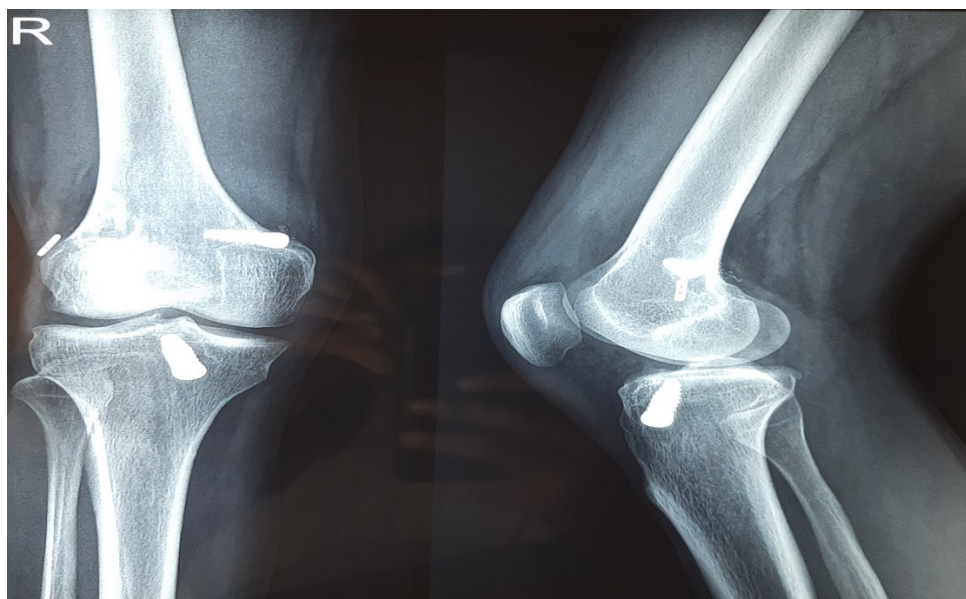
Postop X-Ray (1 Year Follow Up)
